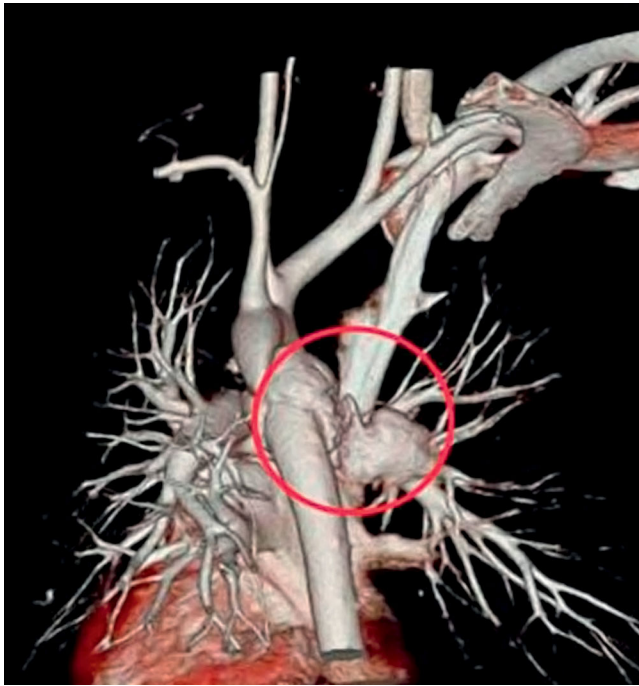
■ CT image with three-dimensional reformation of traumatic thoracic aortic injury with extravasation (*circle*). (From Demetriades D: Blunt thoracic aortic injuries: crossing the Rubicon. *J Am Coll Surg* 214:247, 2012.)
